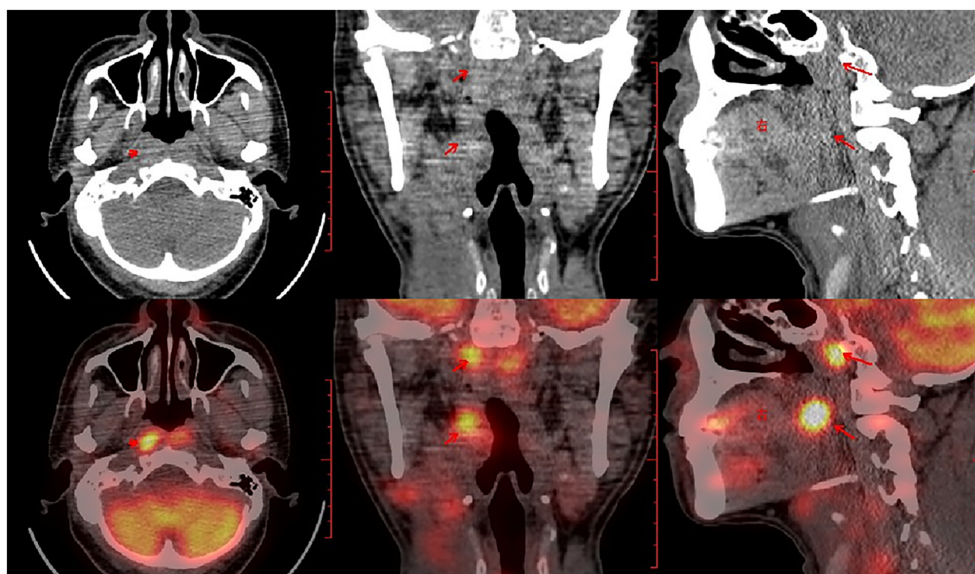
A Whole-body positron emission tomography-computed tomography scan reveals heightened fluorodeoxyglucose drug uptake in the posterior wall of the nasopharynx, the right pharyngeal recess, the right tonsil and the tip of the tongue (SUV_{max} , 17.6).
